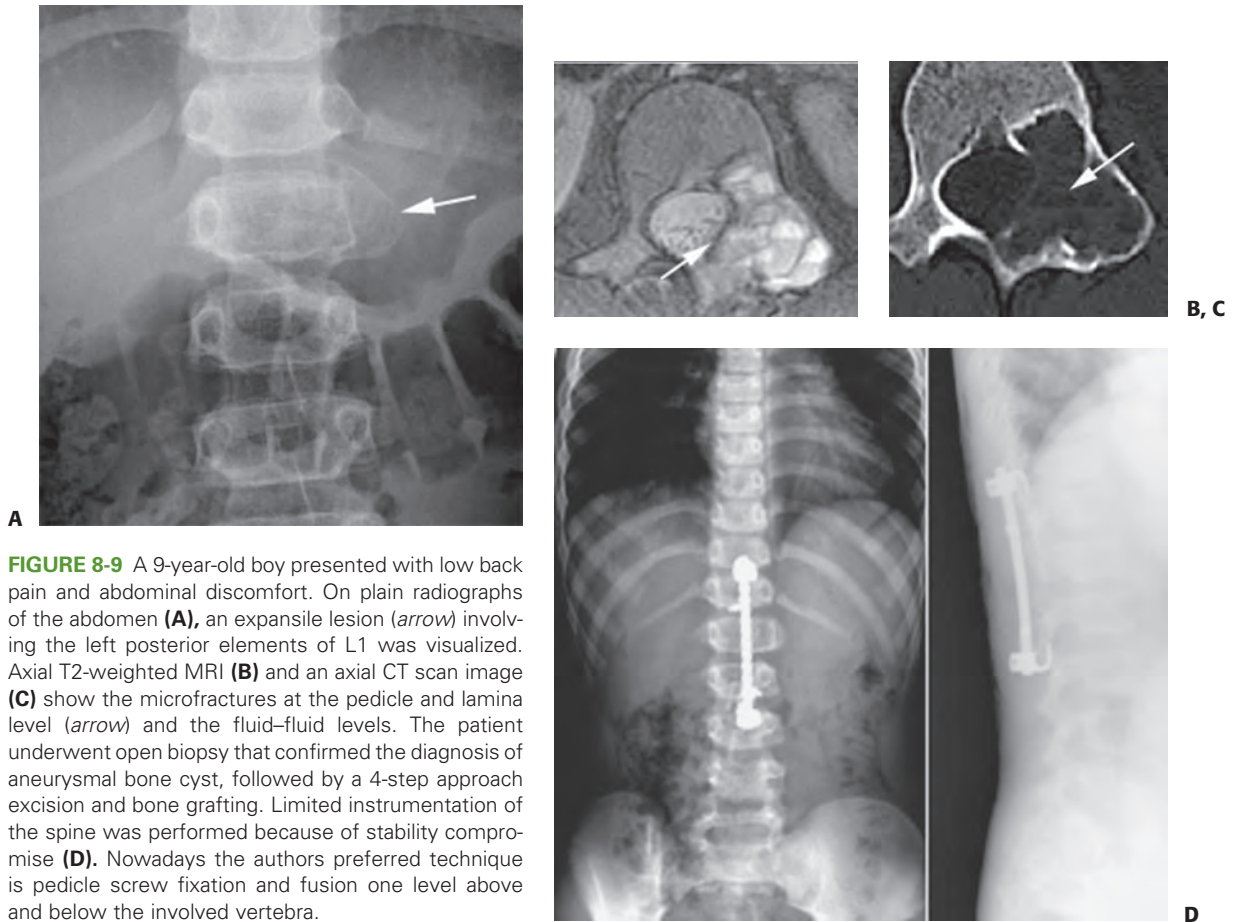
A 9-year-old boy presented with low back pain and abdominal discomfort. On plain radiographs of the abdomen (A), an expansile lesion (*arrow*) involving the left posterior elements of L1 was visualized. Axial T2-weighted MRI (B) and an axial CT scan image (C) show the microfractures at the pedicle and lamina level (*arrow*) and the fluid–fluid levels. The patient underwent open biopsy that confirmed the diagnosis of aneurysmal bone cyst, followed by a 4-step approach excision and bone grafting. Limited instrumentation of the spine was performed because of stability compromise (D). Nowadays the authors preferred technique is pedicle screw fixation and fusion one level above and below the involved vertebra.
